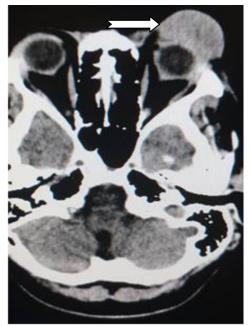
CT axial slice showing a soft tissue mass in the left eye lid (white arrow)
